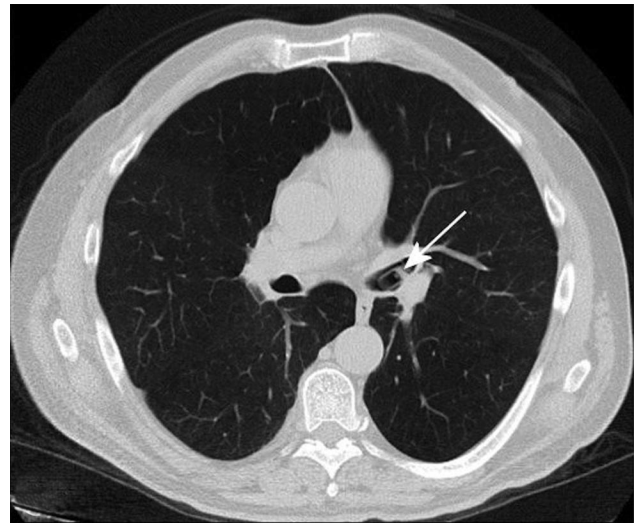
Computed tomogram shows plastic cigarette filter (arrow) in the left main bronchus.
